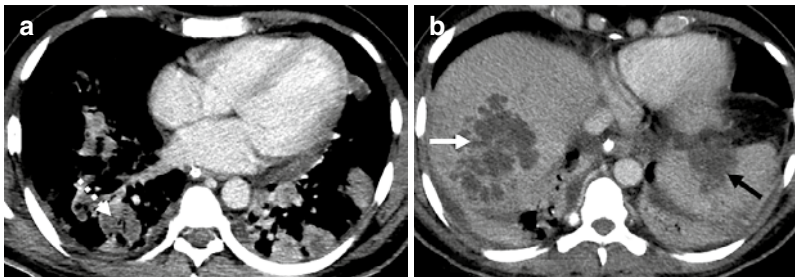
Melioidosis. (a and b) CT images show multiple clustered, coalescing small abscesses with a honeycomb appearance in the liver (white arrow) with a splenic
